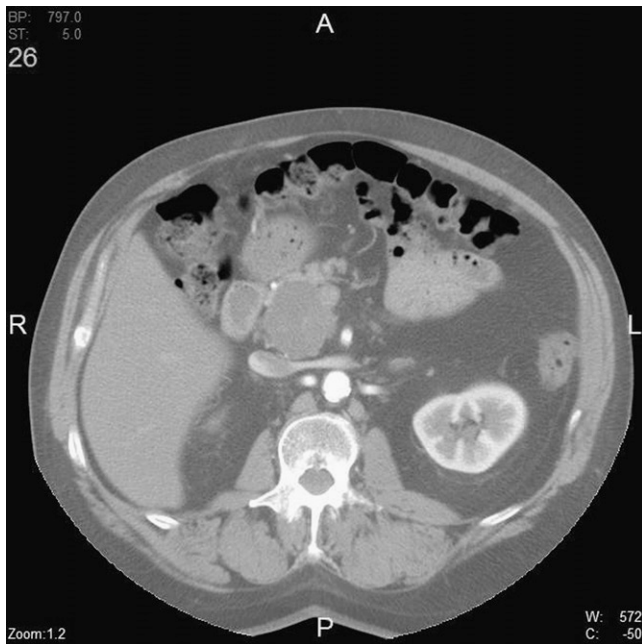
Computed tomography (CT) of the abdomen demonstrating a complex cyst within the pancreatic head and uncinate process (white arrow).
